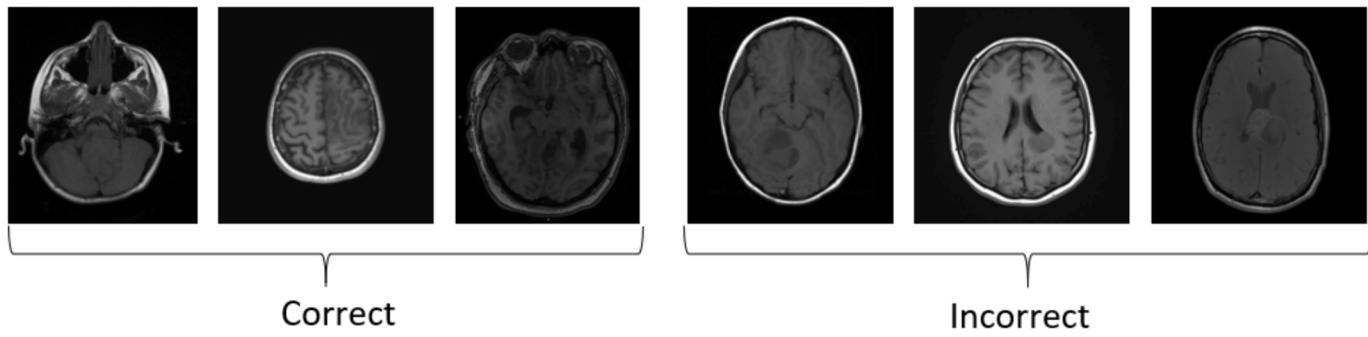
The examples of both successful and unsuccessful classifications of brain MRI within the BM dataset.
